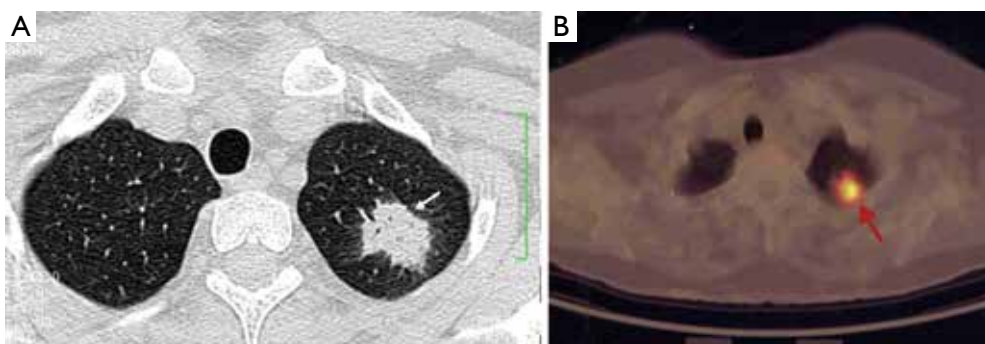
A case of cryptococcal granuloma (arrow) had a SUVmax of 4.5 on the FDG PET scan.
